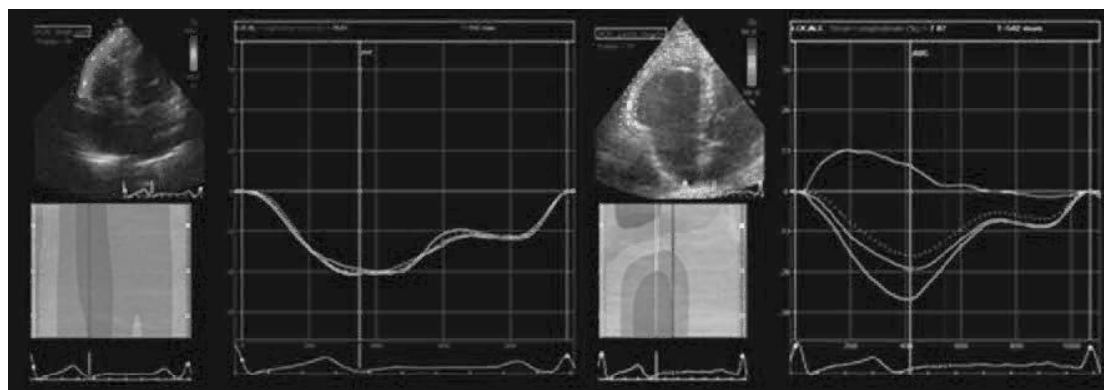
2D longitudinal strain by speckle tracking echocardiography demonstrating RV strain in athlete's heart (on the left) and abnormal RV strain in ARVC in which RVFW strain curves are reduced and show the dispersion of RV contraction. *RV*, right ventricle; *ARVC*, arrhythmogenic right ventricle cardiomyopathy; *RVFW*, right ventricle free wall.
